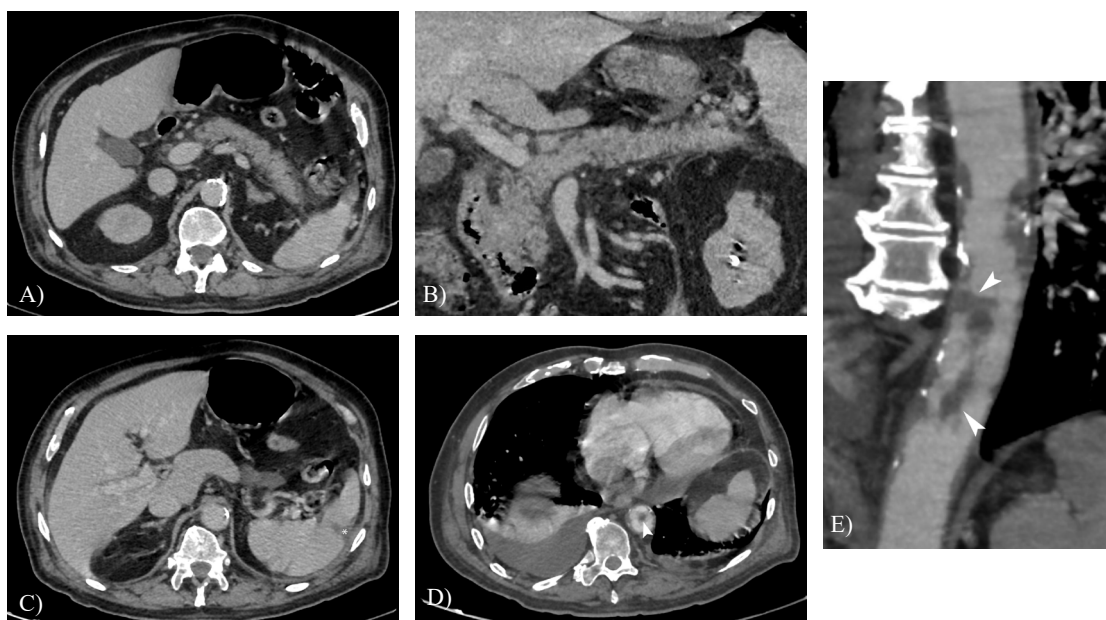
Contrast-enhanced computed tomography of the abdomen at presentation. A) Axial image through the pancreas showing fat stranding and fluid collection in keeping with pancreatitis. B) Curved multiplanar reconstructed image (CMPR) along the pancreas showing fat stranding and fluid collection with a renal infarct (arrowhead). C) Axial image through the spleen showing a wedge-shaped hypodense area suggestive of an infarct (asterisk). D) Axial image through the descending aorta showing an intraluminal filling defect representing thrombus (arrowhead). E) Curved multiplanar reconstruction of the descending aorta confirmed the presence of a free-floating intraluminal thrombus (arrowheads), partially attached to the underlying atherosclerotic lesions (superior arrowhead).
